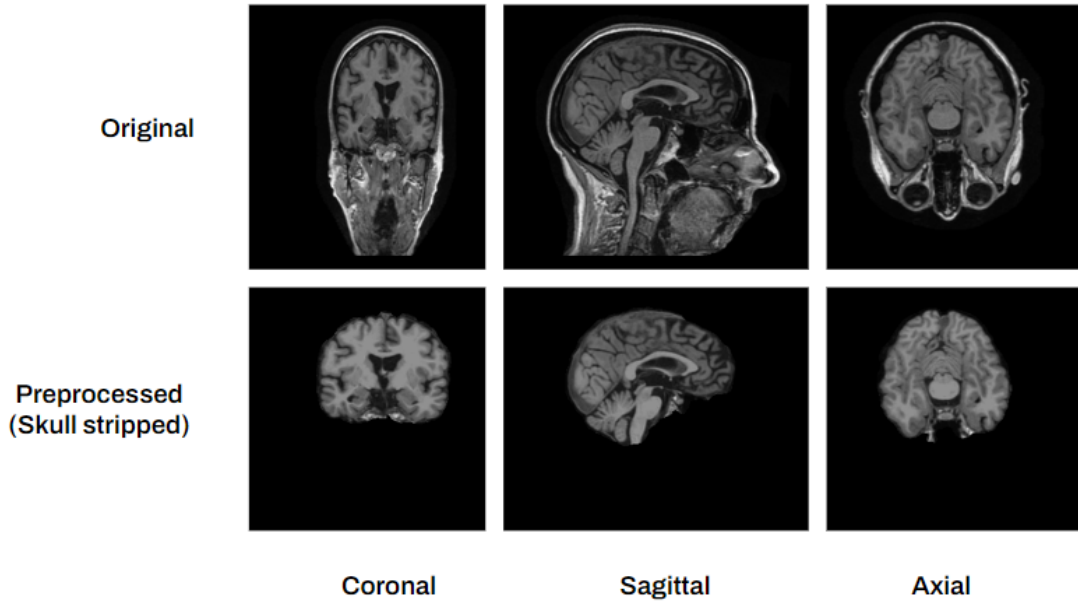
Skull-stripping: The process of removing non-brain tissues from MRI images using semantic segmentation
